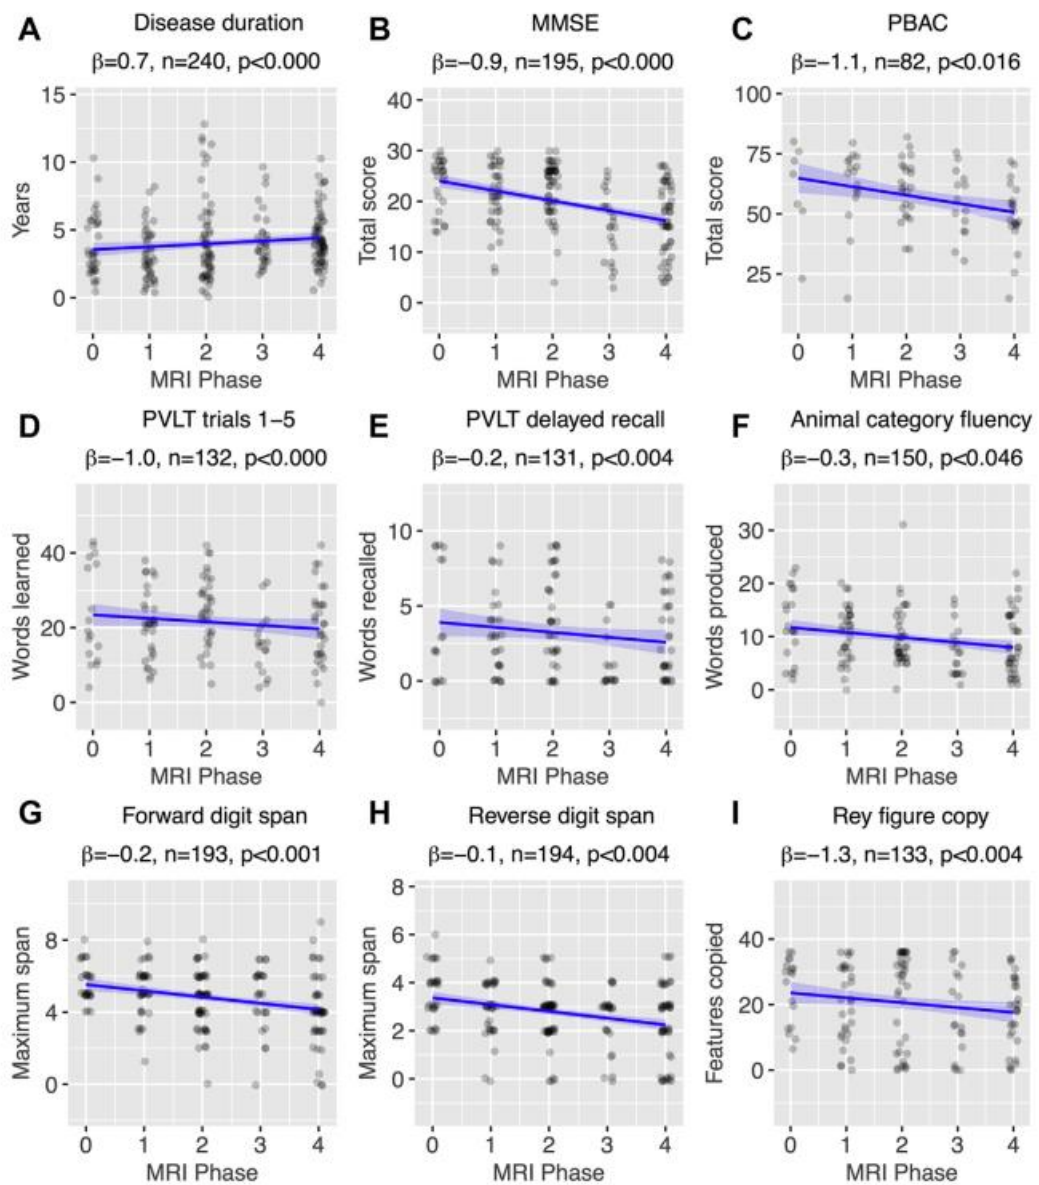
Associations between MRI phase and (A) disease duration or (B-I) neuropsychological performance. Each data point represents a single observation associated with a single scan. All phenotypes are plotted together; the x-axis indicates the MRI phase associated with each scan, as a measure of disease progression. Each plot title includes the regression coefficient for the association with MRI phase, the number of observations in each analysis, and the p-value for the MRI phase regression coefficient. Abbreviations: MMSE, MinieMental Status Examination; MRI, magnetic resonance imaging; PBAC, Philadelphia Brief Assessment of Cognition; PVLТ, Philadelphia Verbal Learning Test.
